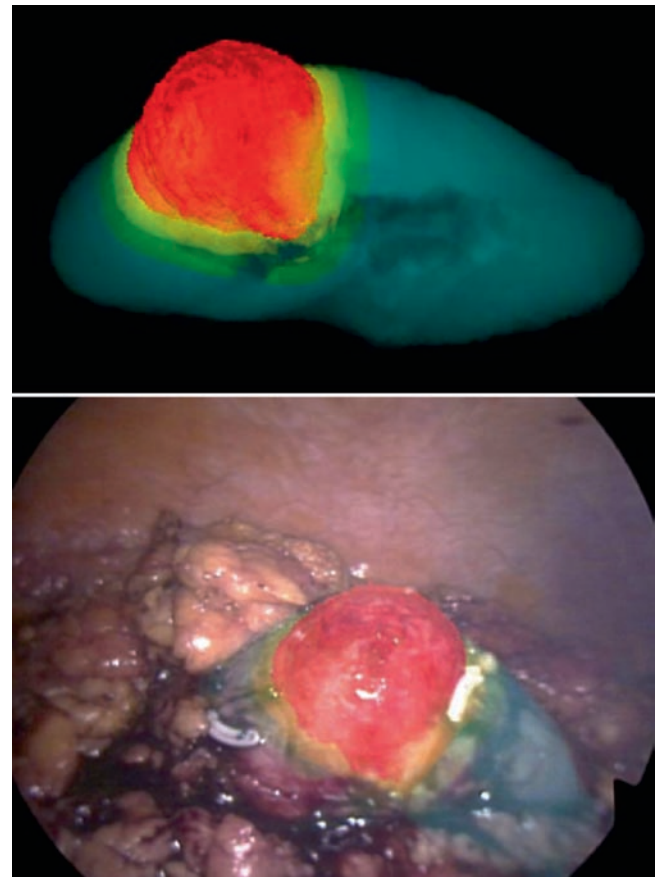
AR visualization (*bottom*) using the 3-D surgical model from original preoperative CT image (*upper*), which is colored by four color-coded-zonal navigation concept, to be superimposed onto the real-time laparoscopic view
